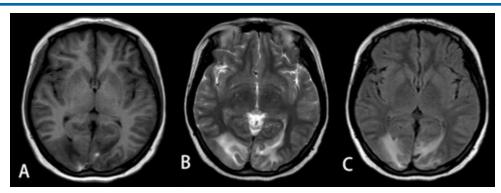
A - Axial T1-weighted image shows bilateral occipital lobe patchy low signal and a small amount of high signal. B - Axial T2-weighted image indicates bilateral occipital lobe patchy high signal lesions. C - Axial T2 FLAIR demonstrates bilateral occipital lobe patchy high signal lesions.
